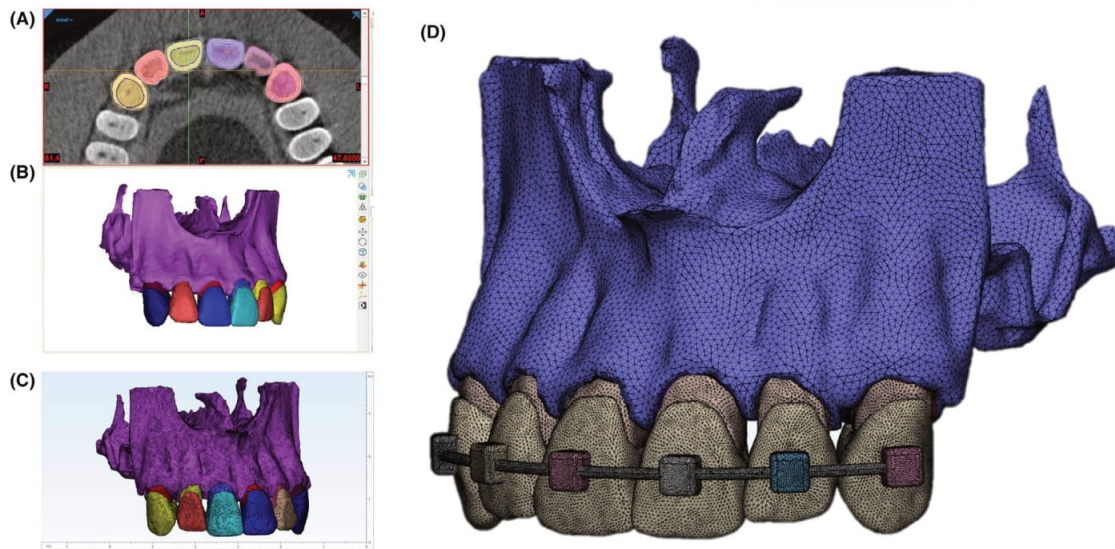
3D model generation. (A) Segmentation performed in Mimics 22.0 software for the various maxillary structures using a CBCT image of a patient with permanent teeth; (B) Volumetric structures generated by segmentation; (C) Unorganized surface mesh imported from Mimics in 3-Matic software; (D) 3D model after the remeshing procedure in 3-Matic with fine density mesh on the teeth and the splint
